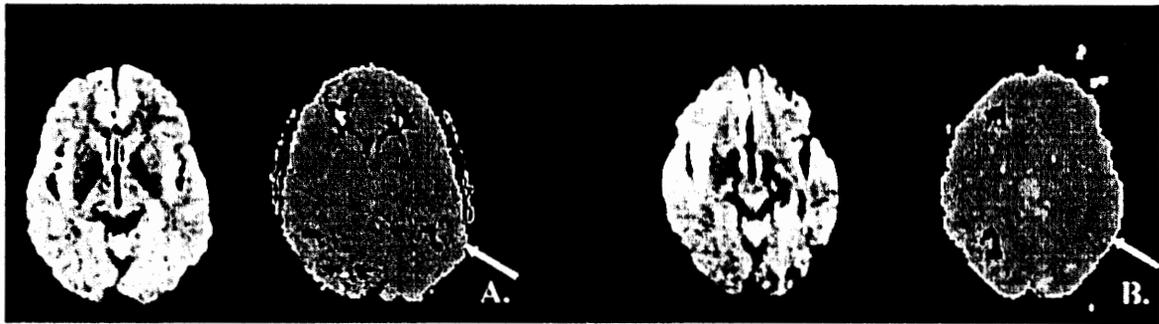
Neurological basis of poor vs. good word comprehenders. Reperfusion of left midfusiform gyrus and surrounding cortex resulted in recovery of naming and reading (Two Left Pannels) DWI (left) and PWI (right) before intervention to improve blood flow. (Two Right Panels) DWI and PWI after intervention. In these and all PWI figures, TTP maps are shown: dark areas are areas of delayed TTP (“hyperfusion”), light areas are areas of relatively normal TTP. The arrow points to left midfusiform gyrus.
